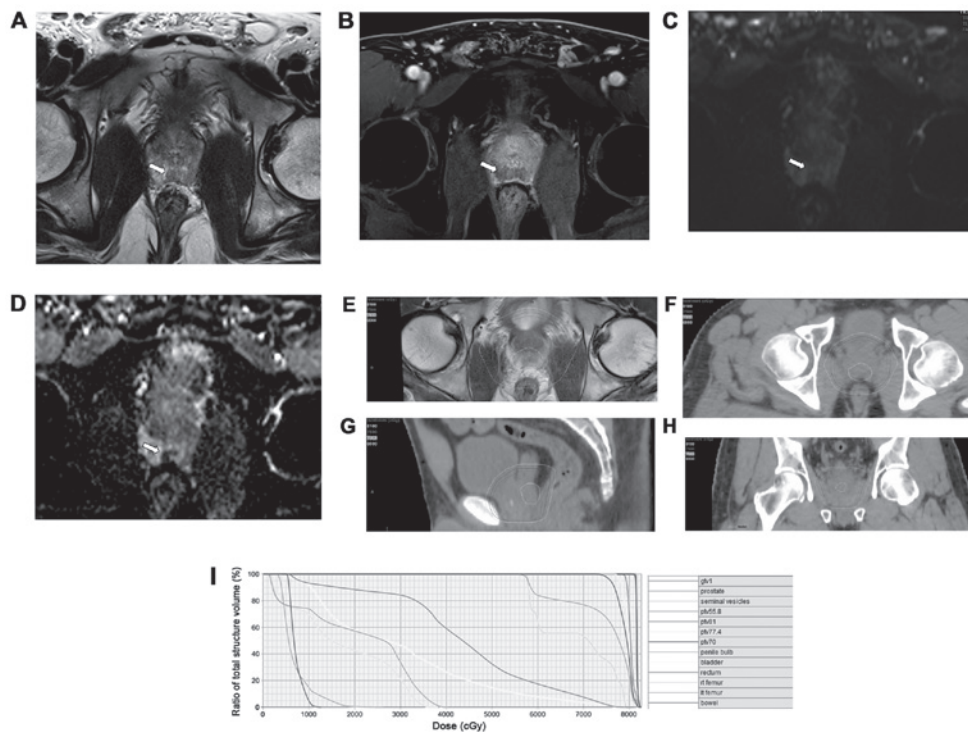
Dose distribution in a representative patient treated with modern intensity-modulated radiation therapy of 81 Gy to the magnetic resonance imaging (MRI) tumor, 77.4 Gy to the prostate, 70 Gy to the proximal seminal vesicles and 55.8 Gy to the seminal vesicles. The patient developed grade 1 acute urinary toxicity and remained alive and biochemically controlled at 17 months after treatment, without late toxicity. Multiparametric prostate MRI showing a dominant mass in the (A) right posterior midline apex on T2-weighted imaging, (B) early dynamic contrast enhancement on T1-weighted imaging, (C) diffusion-weighted imaging and (D) restricted diffusion on the apparent diffusion coefficient map. (E) Axial isodose distribution demonstrating excellent coverage of the MRI nodule to a dose of 81 Gy. (F) Axial, (G) sagittal and (H) coronal dose distribution demonstrated excellent coverage of the prostate >75 Gy, while limiting the maximum rectal and bladder dose to <81 Gy. (I) Dose-volume histogram demonstrates excellent coverage of the PTV81, PTV77.4, PTV70 and PTV54 with selective sparing of the rectal, bladder and penile bulb. GTV, gross tumor volume; PTV, planning target volume.
